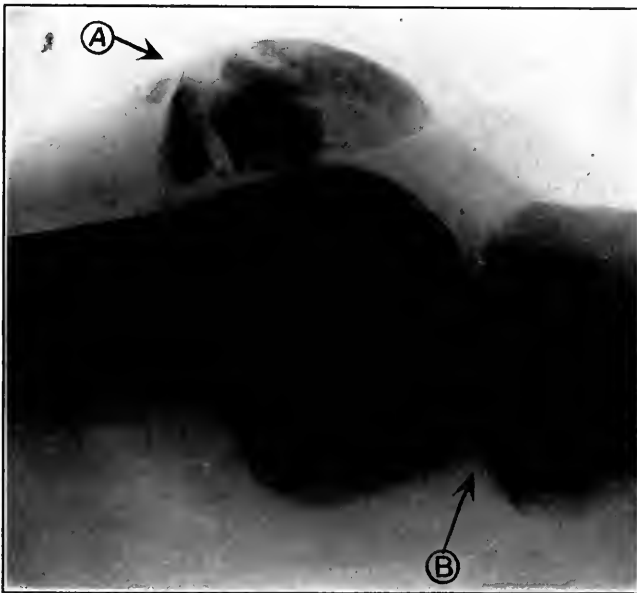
X-ray of knee-joint, showing A, comminuted fracture of patella caused by a bullet, treated by simple immobilization on a Thomas splint, B, points to bony overgrowth of the articular surface of the condyles; however, with vigorous massage and usage, ankylosis was avoided and there was motion of 45 degrees as an end-result, with solid union of patella. This is an exceptional case and the difficulty here was to overcome the secondary changes resulting from prolonged immobilization which had occurred before the case fell into the author's hands. The ordinary case of bullet fracture of the patella should not be immobilized longer than a month. Although no set rule can be laid down, active flexion and passive extension should be instituted early.
